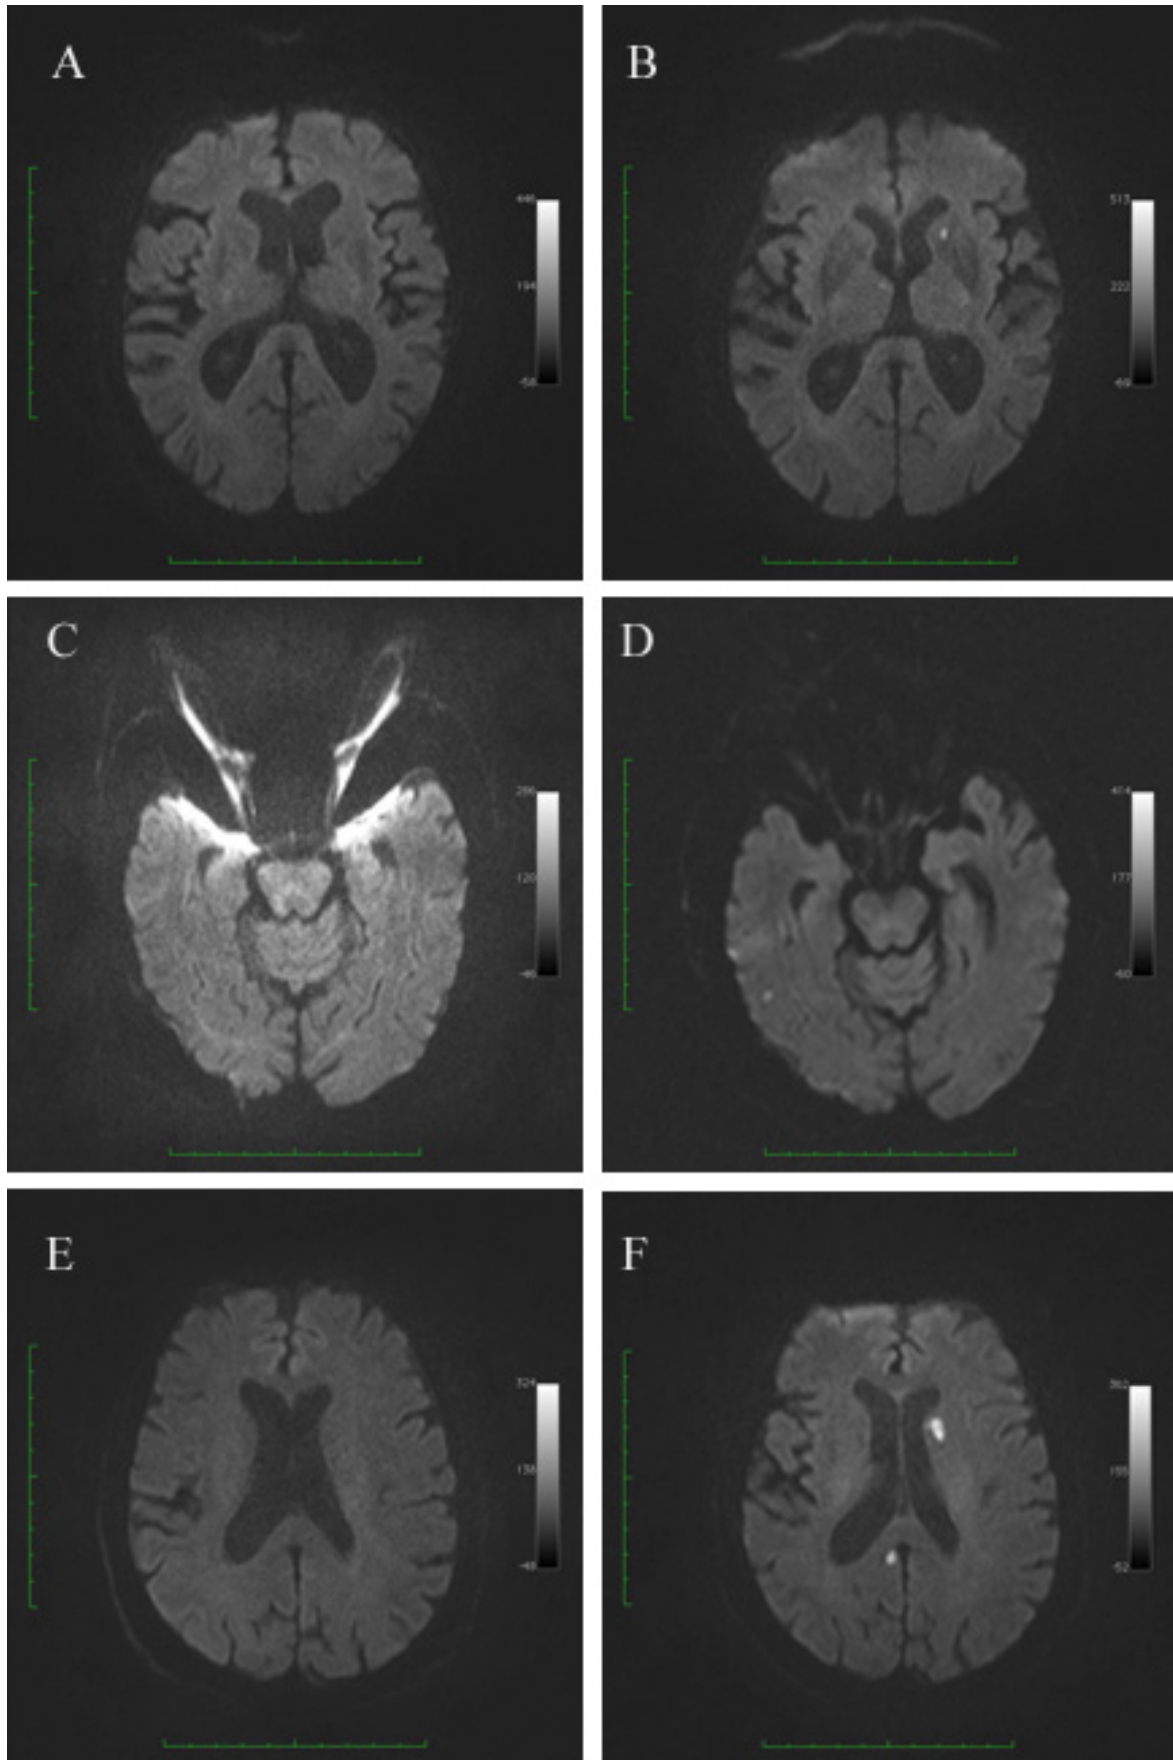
Pre- (A,C,E) and postinterventional (B, D, F) DW MRI. Classification from top to bottom I, II and III accordingly.
